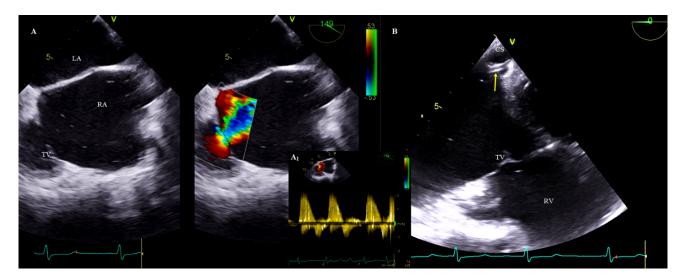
Evaluation of the tricuspid valve after TLE for massive lead-dependent TV regurgitation. (A) Two-dimensional TEE mid-esophageal projection, color Doppler. After TLE, the tricuspid valve regurgitation reduction was assessed based on the VC area (compared to Fig. 2—the same patient). (A1) Two-dimensional TEE, CWD. The well-saturated Doppler spectrum of the tricuspid regurgitation with low velocity indicates severe regurgitation of the TV. (B) Implanting a left ventricular lead (yellow arrow) to bypass the tricuspid apparatus. RA, right atrium; RV, right ventricle; CS, coronary sinus; TV, tricuspid valve; LA, left atrium; CWD, continuous wave Doppler; TEE, transesophageal echocardiography; TLE, transvenous lead extraction.
